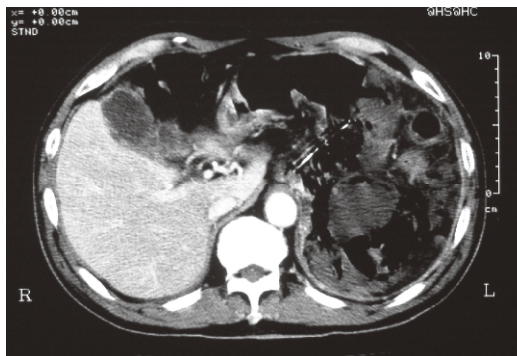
After 10 days, CE-CT showed spontaneous rupture of the pseudocyst into the stomach and free air in the pseudocyst.
